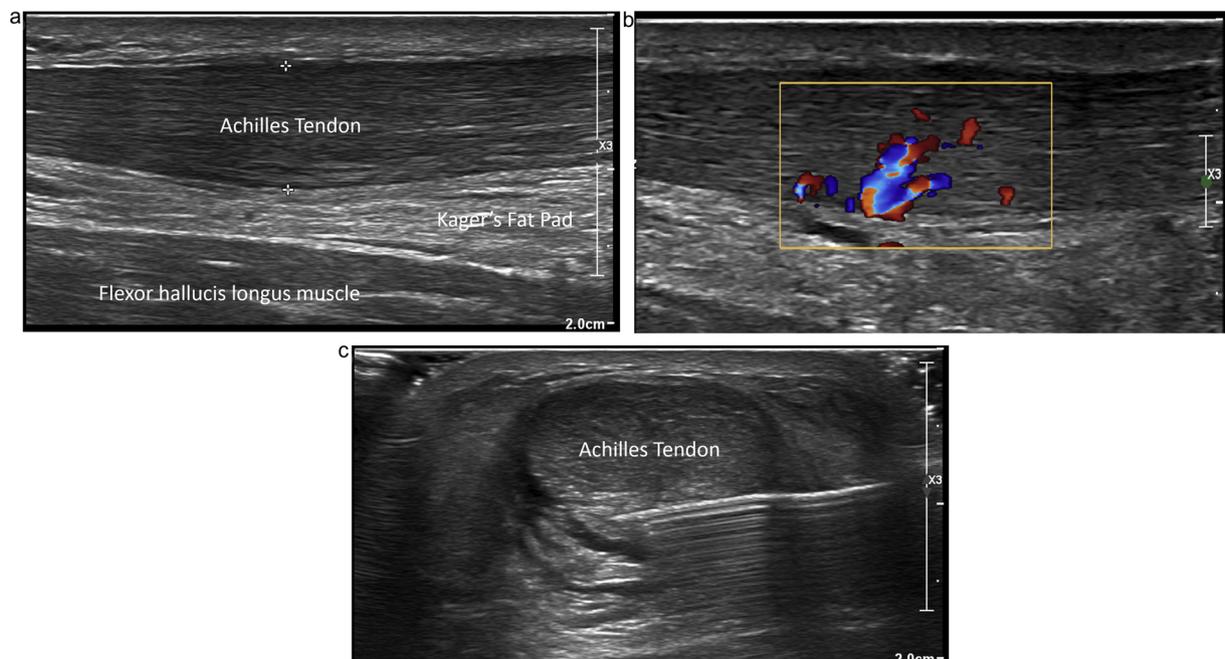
33-year old male marathon runner with mid-Achilles pain. (a) Longitudinal B-mode sonogram demonstrating fusiform expansion of the Achilles tendon consistent with non-insertional tendinopathy. (b) Longitudinal Doppler sonogram demonstrating branching neovascularisation. (c) Transverse sonogram demonstrating 21 gauge needle tip position on ventral surface of Achilles tendon during high volume injection (HiVI).
